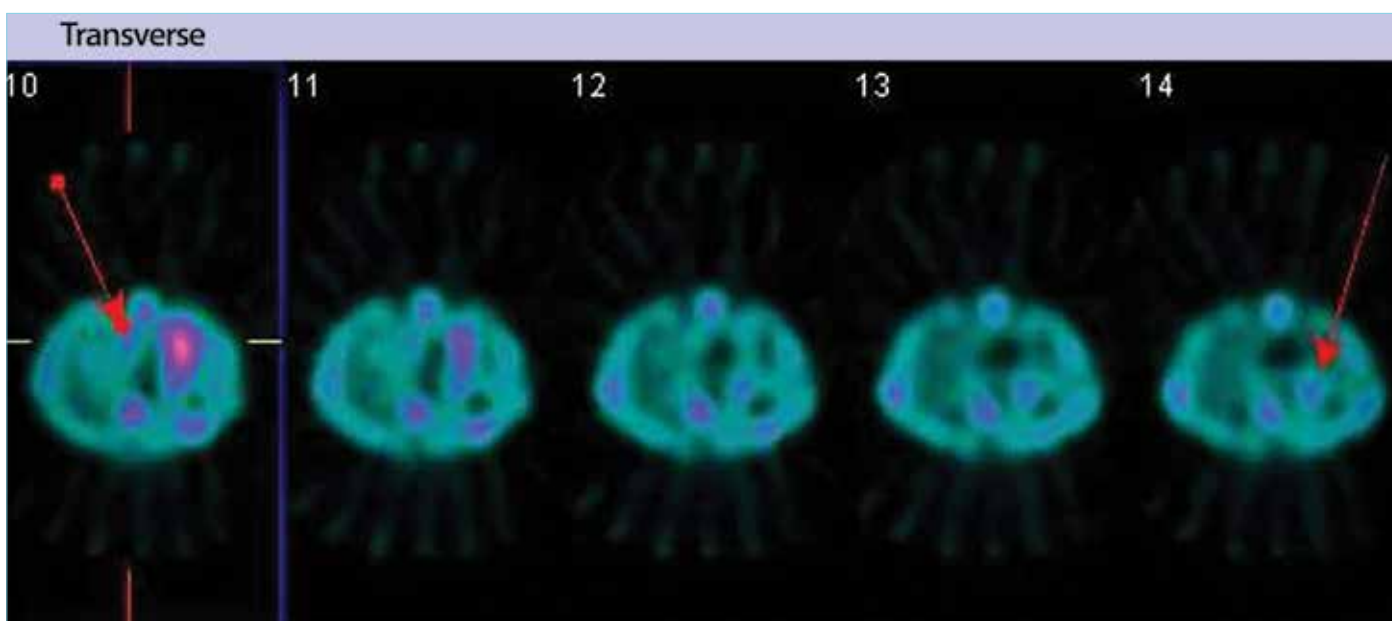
a, b. Image of 63-year old man with adenocarcinoma of the right upper lobe. (a) Contrast material-enhanced CT scan shows a right paratracheal node. (b)  $^{99m}\text{Tc}$ -MIBI SPECT shows increased abnormal accumulation corresponding to the mediastinal lesion (MIBI MLN ratio =1.45) (red arrow). Reactive and anthracotic lymph node was determined by mediastinoscopy. False positive result was detected with  $^{99m}\text{Tc}$ -MIBI SPECT
